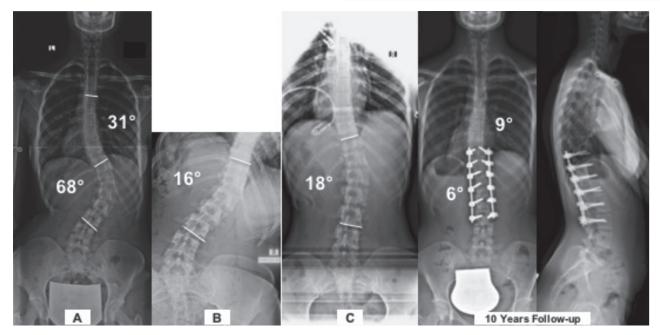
A patient with a 10 years follow-up. The patient was 16 at the age of surgery. A: Standing full spine anteroposterior X-ray; B: Preoperative supine bending X-ray; C: Traction anteroposterior X-ray under general anesthesia and last follow-up anteroposterior and lateral standing spine X-rays
